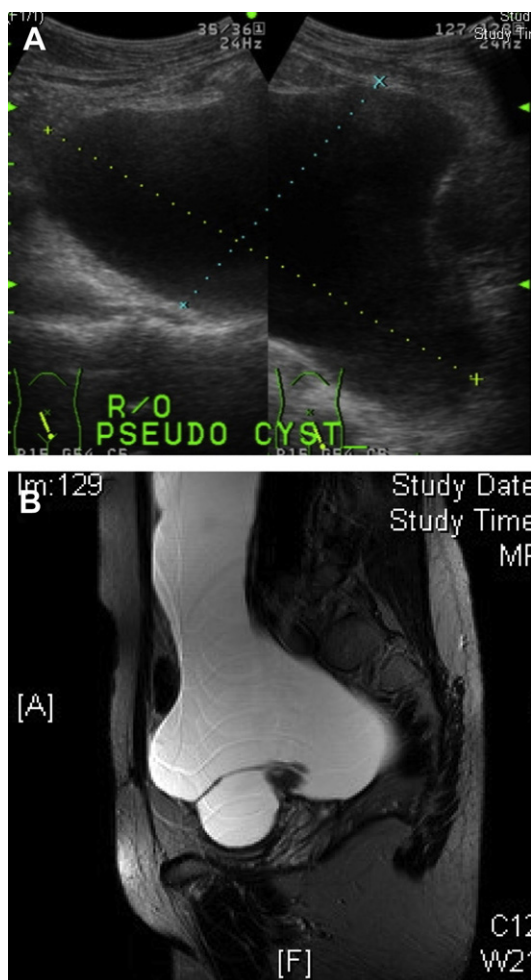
Pelvic pseudocyst. (A) Transabdominal ultrasonographic image showing an irregularly shaped cystic lesion with thickened walls. (B) Sagittal T2-weighted MR image showing a large pelvic inflammatory cyst in the lower part of the abdomen.
